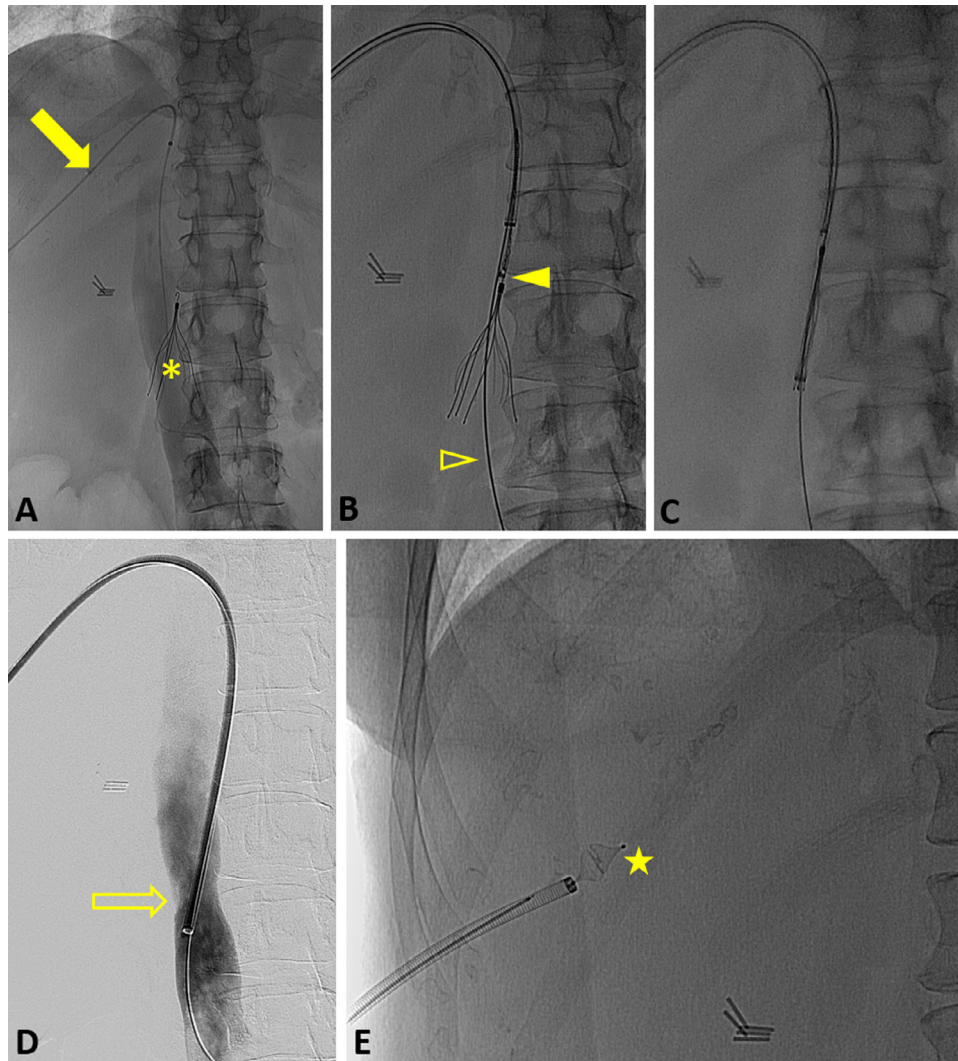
Transhepatic IVC filter removal. (A) Inferior vena cavogram performed via percutaneous antegrade access into the middle hepatic vein (arrow) demonstrates the presence of an IVC filter (asterisk) without IVC stenosis or filling defects. (B) A spot radiograph demonstrates a snare device tightly engaging the filter hook (arrowhead). A stiff safety wire (open arrowhead) was placed alongside the snare and down the IVC to avoid kinking of the sheath and increase the stiffness of the system. (C) A fluoroscopic image demonstrates complete collapse of the filter within the sheath. (D) Digital subtraction cavogram immediately post filter removal demonstrates minimal narrowing of the IVC at the level of the filter feet without tear or extravasation. (E) A final spot radiograph demonstrates an Amplatzer IV plug (AVP4; St. Jude Medical, Plymouth, MN) deployed within the parenchymal tract (star) prior to sheath removal. IVC, inferior vena cava
